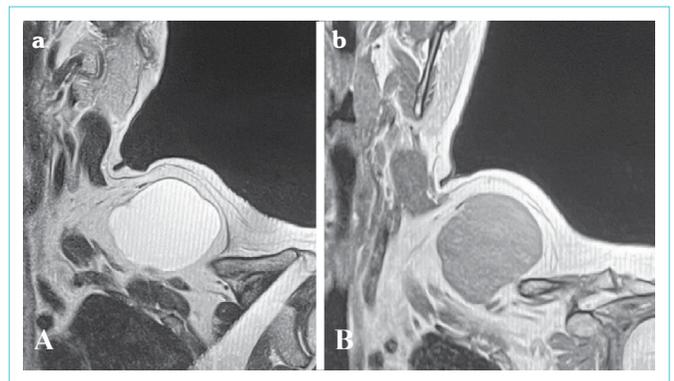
Magnetic resonance image of the neck in the coronal view, demonstrating a well-lobulated cystic lesion, which is hyperintense on T2 sequence imaging (a) and hypointense on T1 sequence imaging (panel b)
